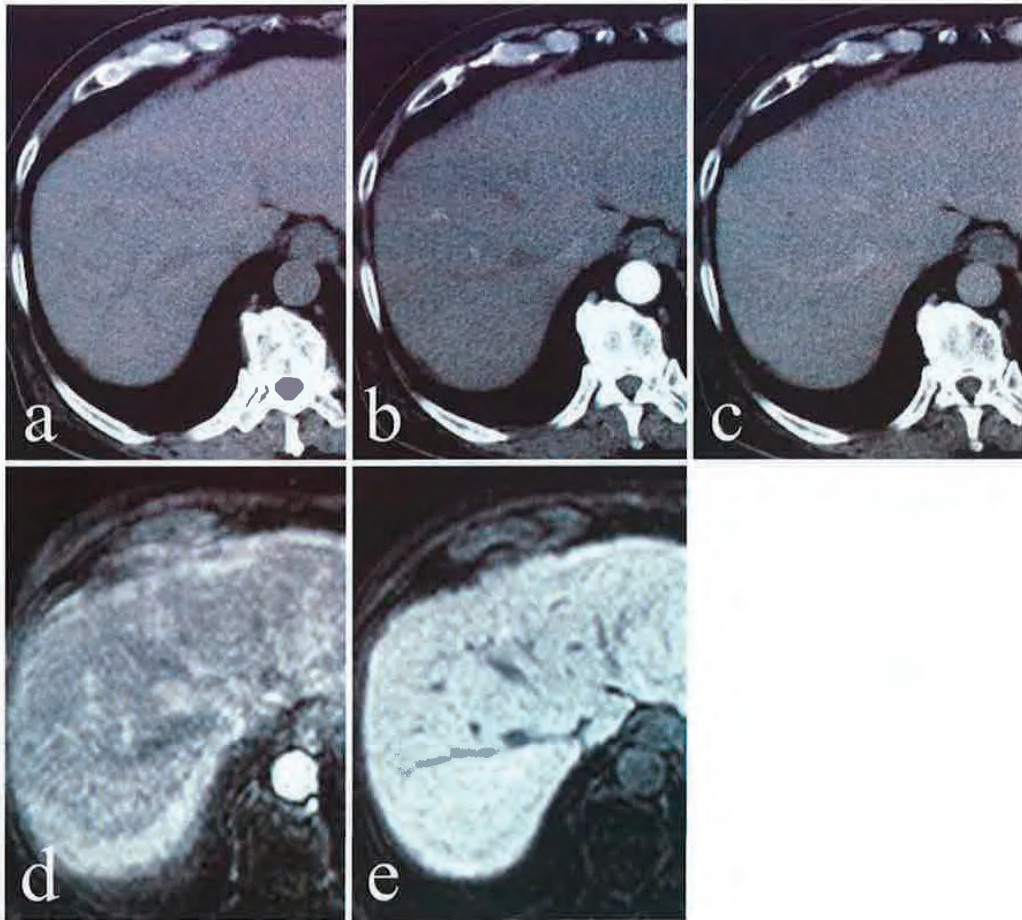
Imaging findings of CT and MRI. (a) Plain CT reveals no fatty liver or any nodule in the liver. (b) Contrast-enhanced CT reveals no enhanced nodule in the arterial phase and (c) no wash-out in the equilibrium phase. CT imaging was performed with Somatom Emotion 16-Slice configuration (Siemens Japan). (d) Gd-EOB-DTPA-enhanced MRI reveals no enhanced nodule in the arterial phase and (e) no defect in the hepatobiliary phase. MR imaging at the hepatobiliary phase was performed with Gyroscan 10T-NT (Philips Medical Systems), Intera 1.0T version 12.1. THRIVE; TR/TE: 5.4/2.8 msec, FA: 20°, SENSE factor: 2, slice thickness: 6 mm (gap -2.5 mm), slice number: 70, matrix: 160×512
